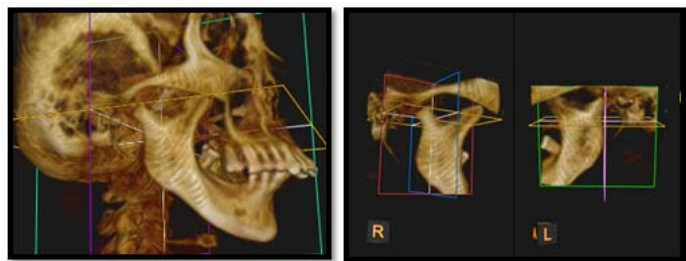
CBCT showing three dimensional reconstruction in the sagittal plane showing flattening of right and left side of condylar head.
